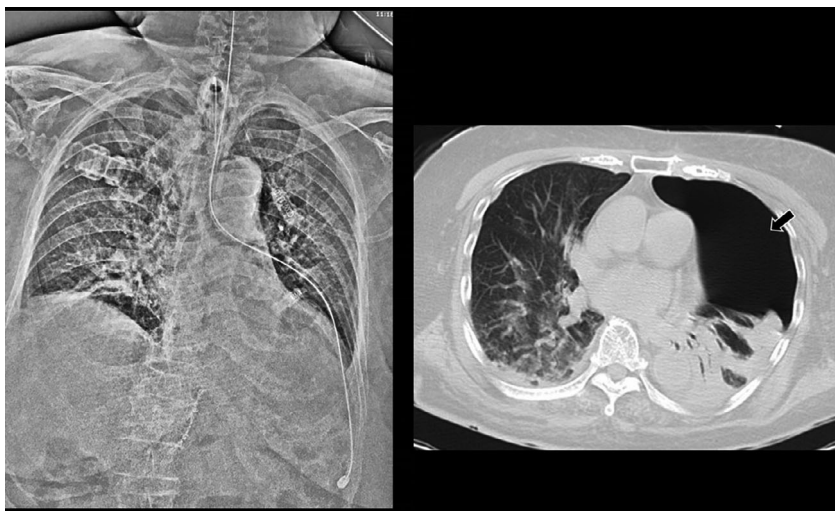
Chest X-ray (left panel) and computed tomography scan (right panel) of an 85-year-old woman show the incorrect insertion of a nasogastric tube and subsequent pneumothorax (arrow).
